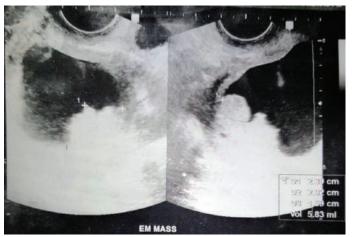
Transvaginal ultrasound showing endometrial mass with ore than 50% myometrial invasion, possible hydrometra
